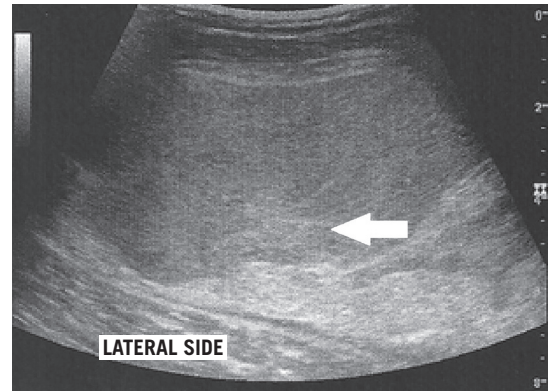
Ultrasonography demonstrating heterogeneous well-delineated mass, with hyperechoic area inside (white arrow)
